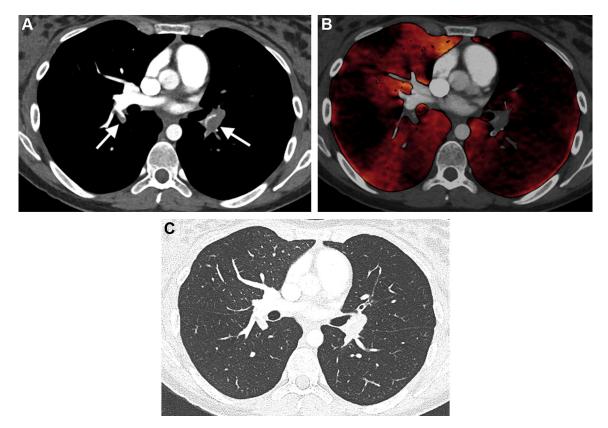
A, Axial CT pulmonary angiographic image on mediastinal windows in a 24-y-old woman with acute pulmonary emboli showing bilateral central expansile pulmonary arterial filling defects (arrows). B, Axial postprocessed iodine perfusion map in the same patient showing extensive perfusional defects in both lungs. C, Axial CT image of chest in the same patient showing no evidence of mosaicism.
